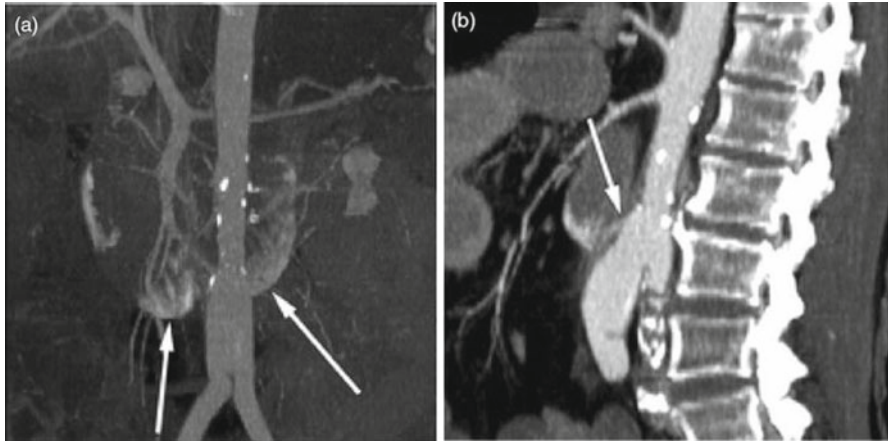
Aortoduodenal fistula in a 70-year-old man 10 years after aortoiliac graft implantation: (a) contrast-enhanced axial CT with extravasation of contrast into duodenum; (b) contrast-enhanced sagittal view showing location of fistula. From Frauenfelder et al. [34]
